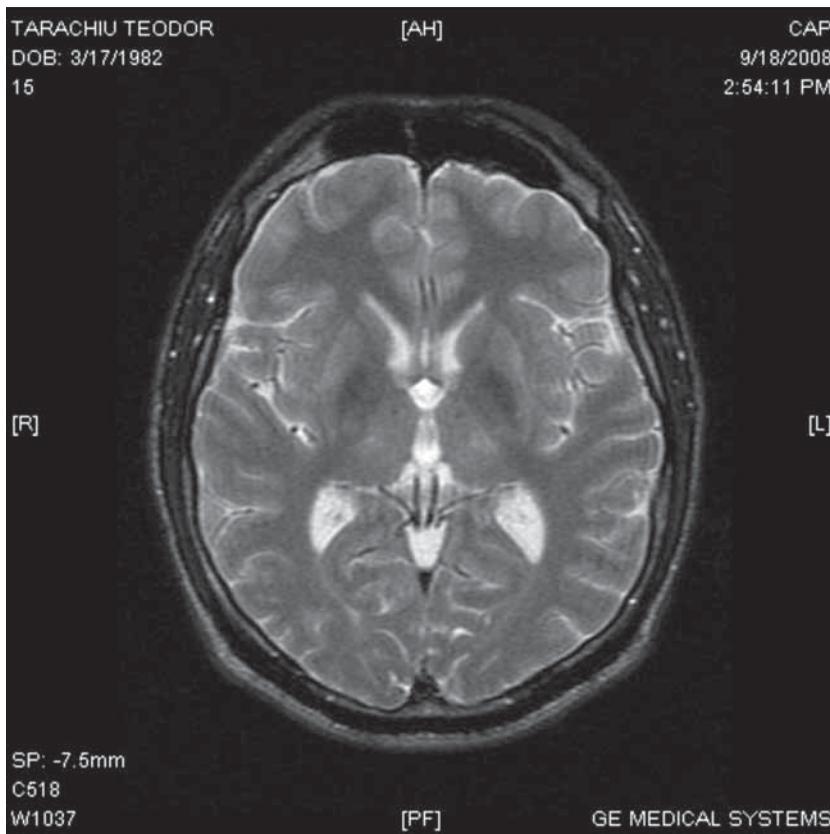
Cerebral MRI reveals FLAIR bilateral hypersignal bands of spino-thalamic tracts
